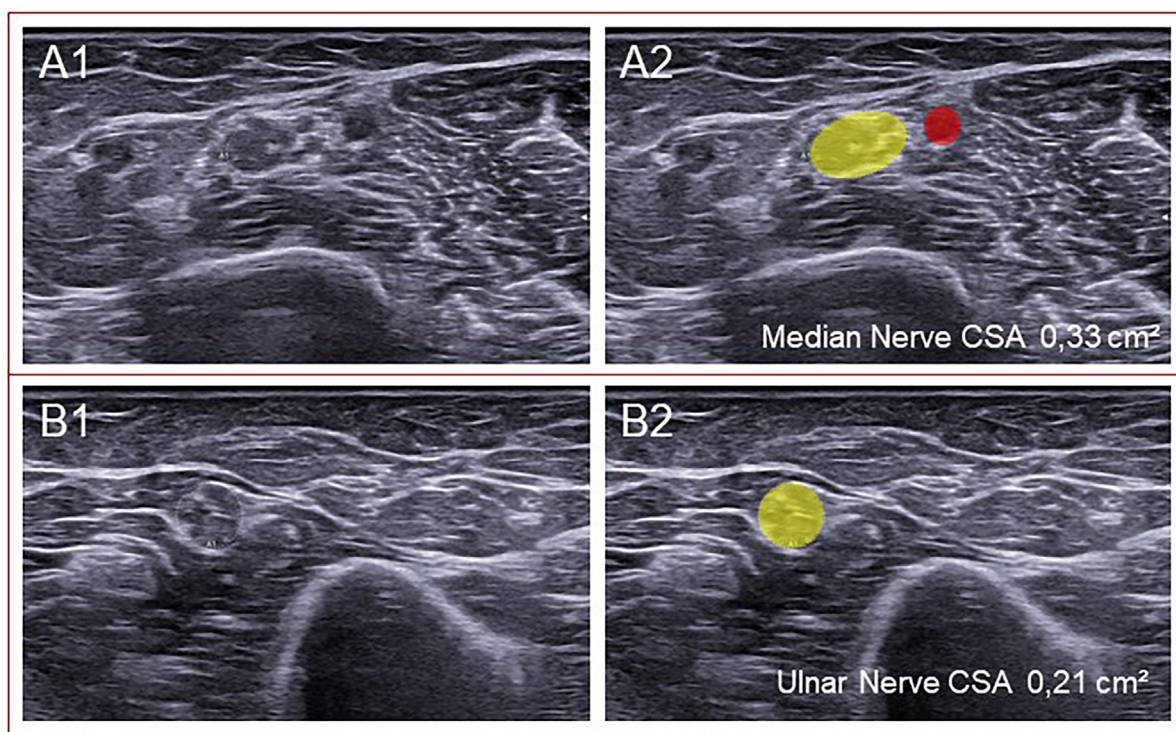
High-resolution nerve ultrasound examination showing an enlarged median (A) and ulnar (B) nerves at the arm in Friedreich's ataxia. Yellow circles indicate the nerves and red circle indicate the artery.
